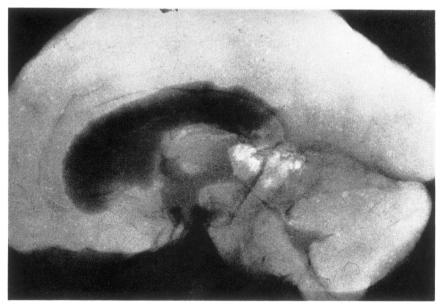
Same case as in Figure 5. A roentgenogram of the brain, postmortem, showing the ballooned-out third ventricle, and the thin, elongated aqueduct of Sylvius.
